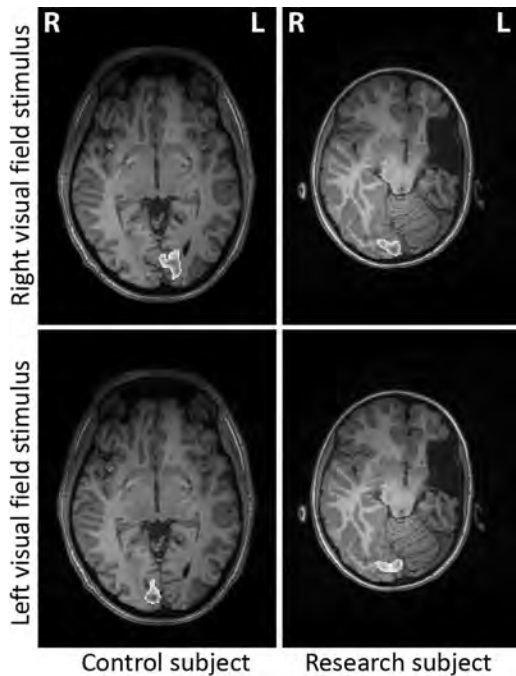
The axial T1 MRI overlaid with functional data, with a control subject on the left for comparison.
